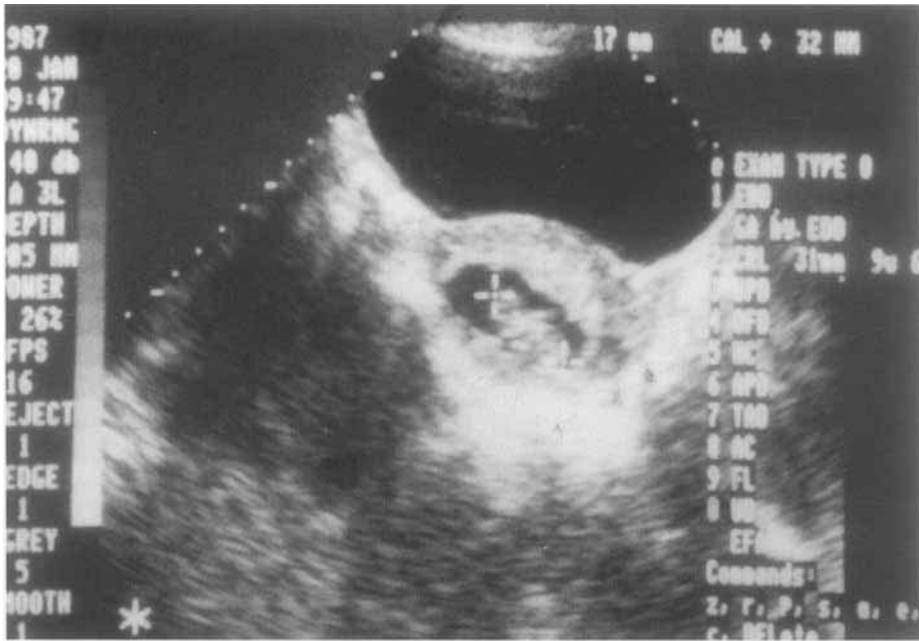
Abdominal ultrasound showing single intrauterine pregnancy in spouse of patient 2.
